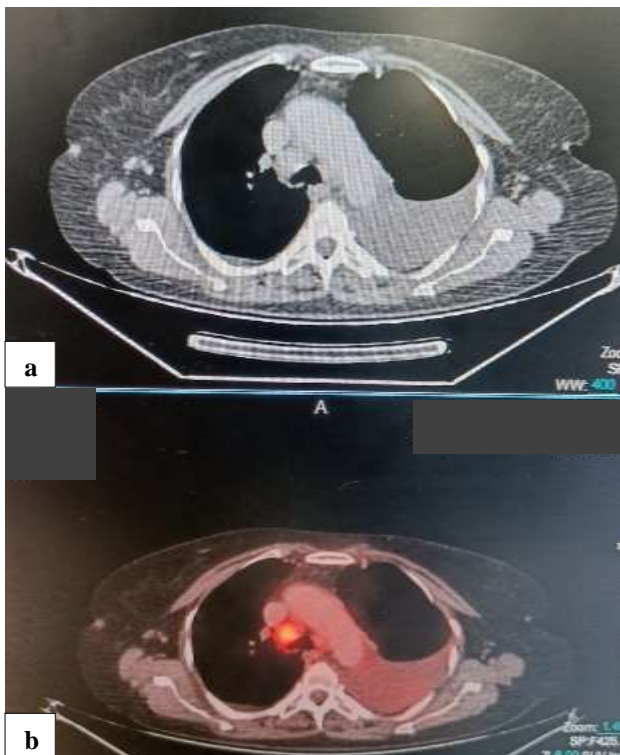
(a) CT chest showing mediastinal lymphadenopathy and pleural effusion, and (b) PET CT showing increased FDG uptake in the right mediastinal node with no active uptake in the pleural effusion.
